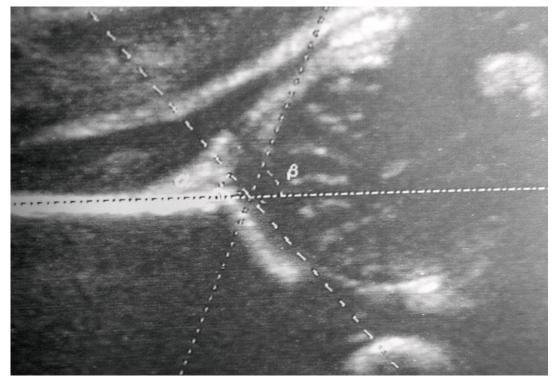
An ultrasound image of current study showing 8 day-old-boy with Graf Type-III Alpha 44 & Beta 81 (Eccentric Hip).
